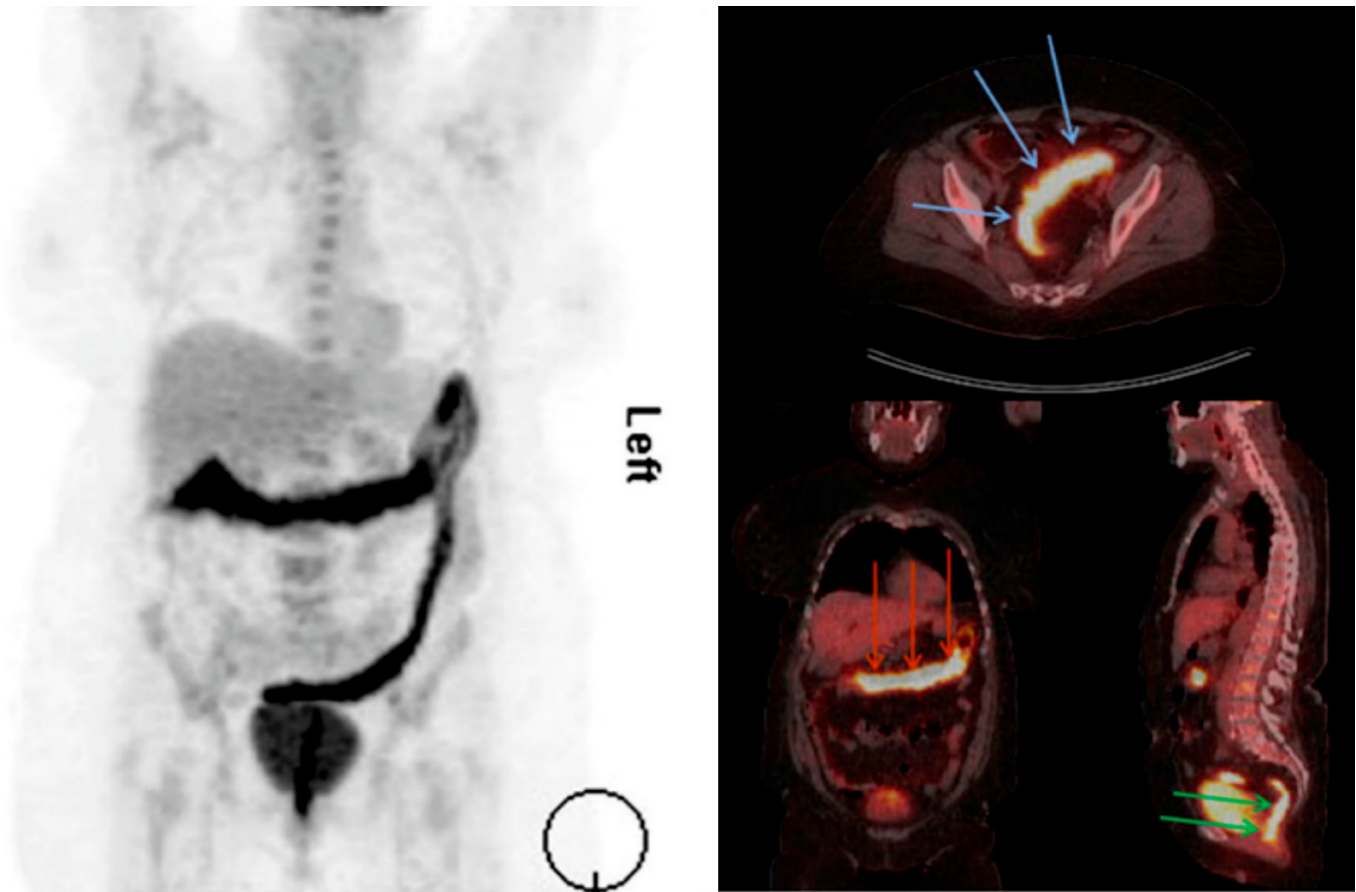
18F-FDG PET/CT scan of UC patient. Axial view on the left depicts the extent of disease and inflammation. Right panel shows additional coronal, axial, and sagittal views of the extent of disease. Image reused from [114].
